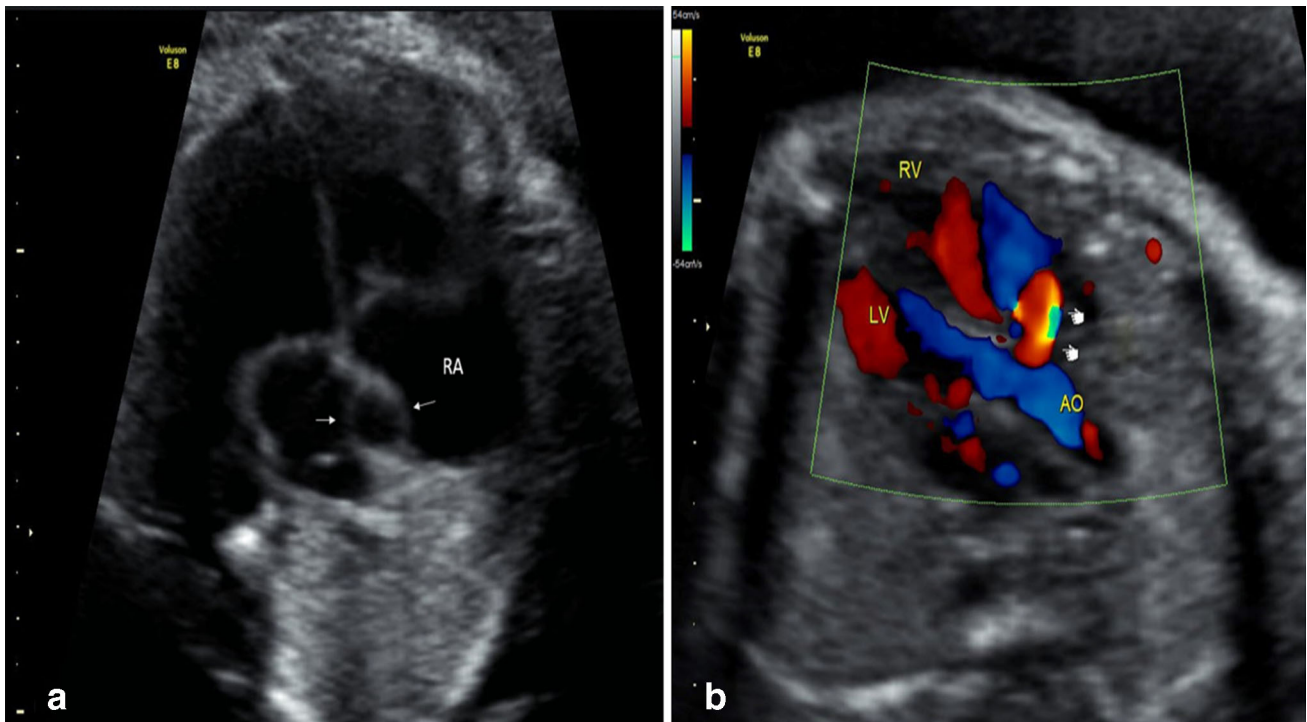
a Apical four-chamber view in fetal echocardiography showing circular cystic structure (*arrows*) close to the interatrial septum in the right atrial cavity. b Color Doppler in left ventricular
